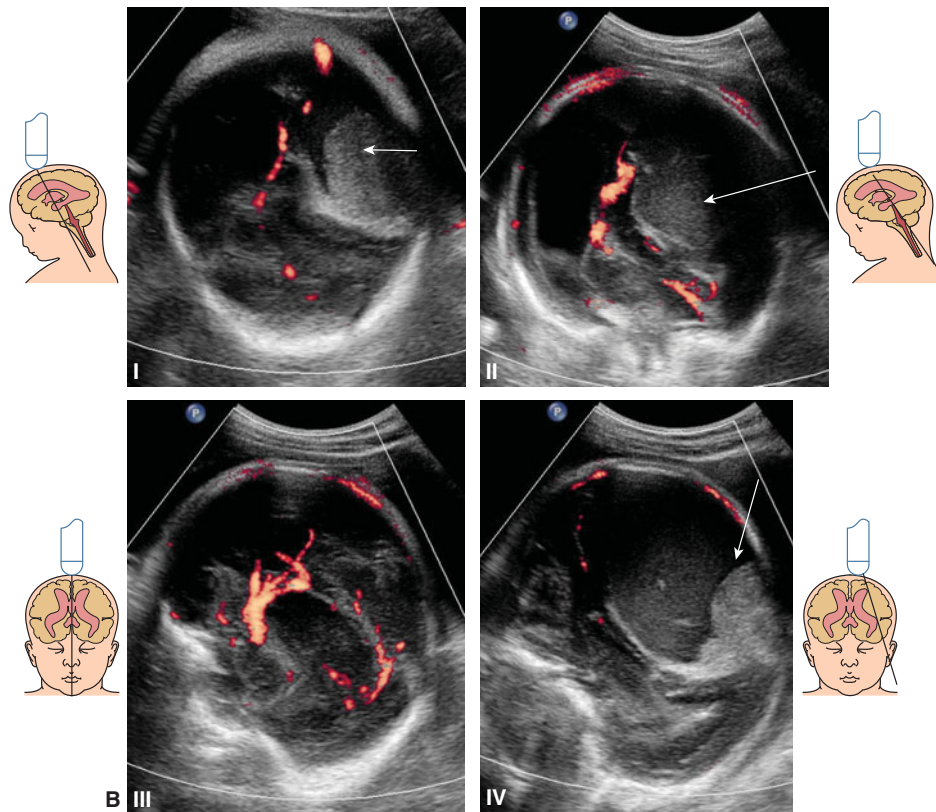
(continued) (B) Power Doppler imaging of I left-sided temporoparietal subdural hematoma: (I and II) coronal sections (III) and (IV) are median and left parasagittal, respectively. The arrow points to the hematoma and the hyperechoic clot distorting the course of the vessels. (C) Biometry of the fetus. Note the enlarged fetal head measurements. Inlay: Electronic monitoring demonstrates decreased short-term fetal heart rate variability and a sinusoidal pattern.
